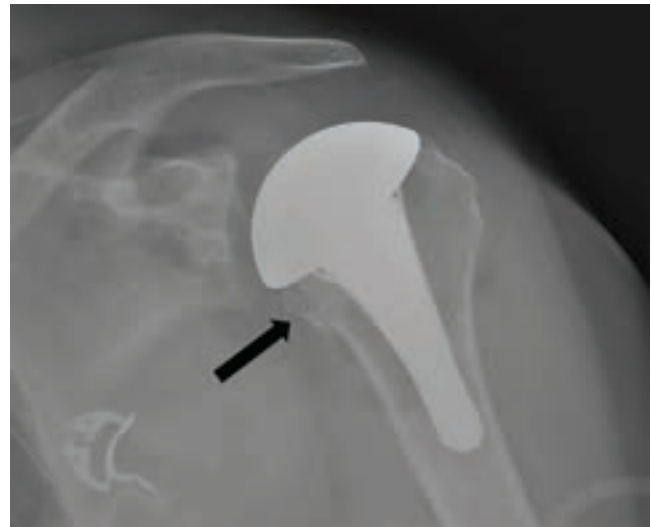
X-Ray showing the minimally displaced lesser tuberosity osteotomy site.
